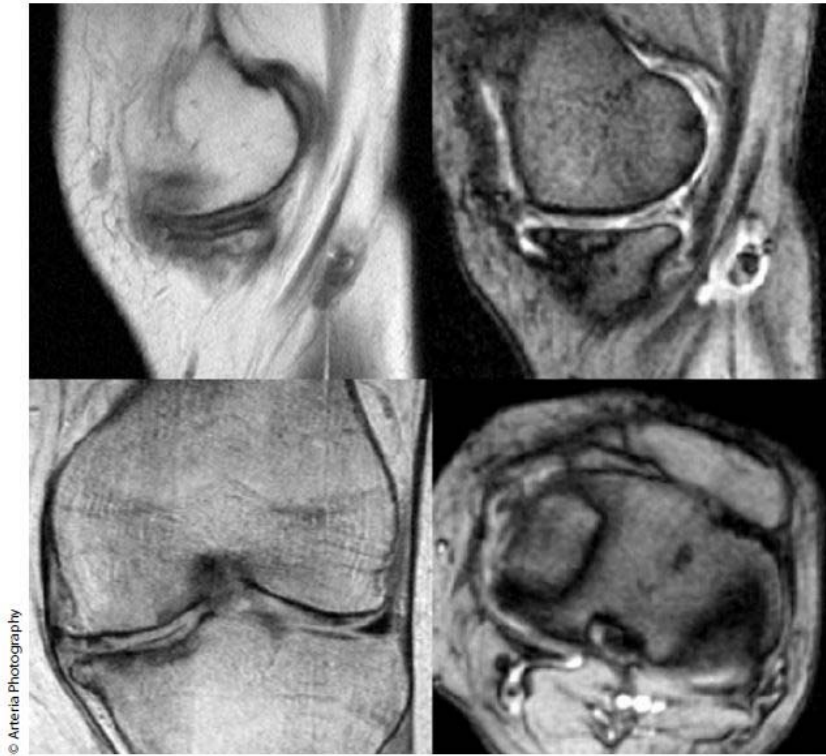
MRI images of gonarthrosis
